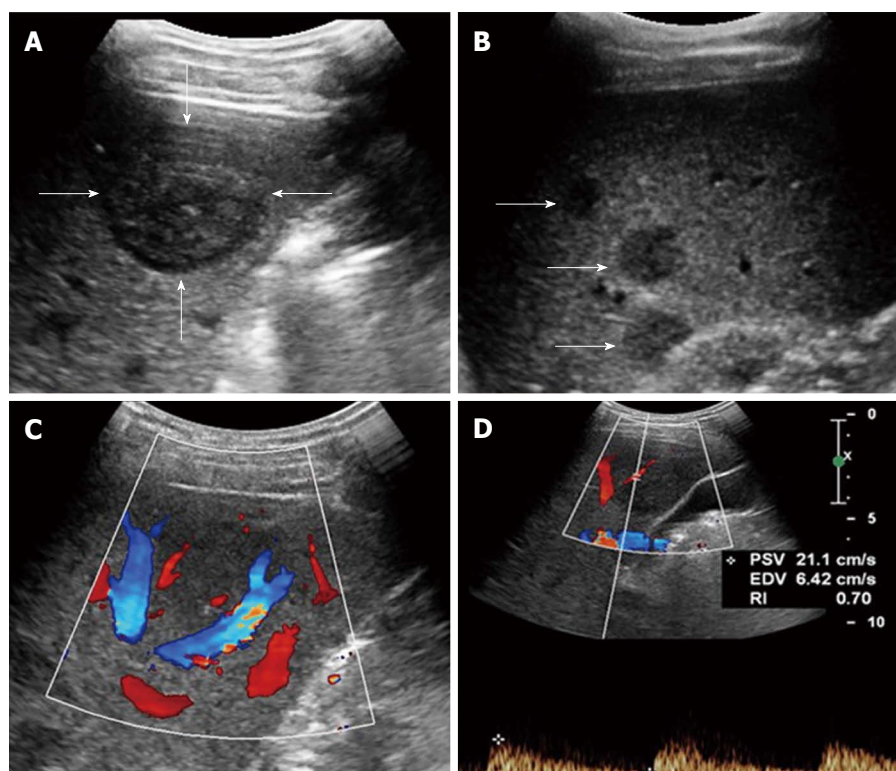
Multiple hepatic epithelioid hemangioendotheliomas in a 31 year female. A: Grayscale ultrasound showed a distinct hypoechoic focal liver lesion (FLL) (arrow); B: Multiple hypoechoic lesions (arrows) were also detected in this patient; C: Color Doppler imaging (CDFI) showed peripheral and intra-lesion color flow signals; D: The resistive index (RI) of color flow was 0.70.
